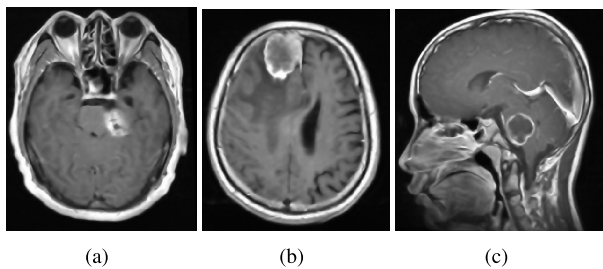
Brain MRI images of three planes namely axial plane as shown in Fig(b), sagittal plane as shown in Fig(b) and coronal plane as shown in Fig(c).
